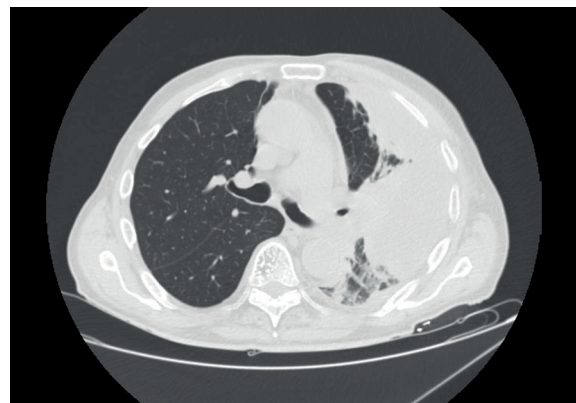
Chest CT scan showing left empyema.
